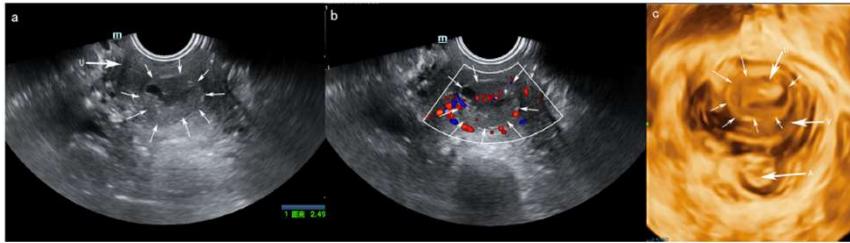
Sonographic characteristics of female urethral and peri-urethral masses.
